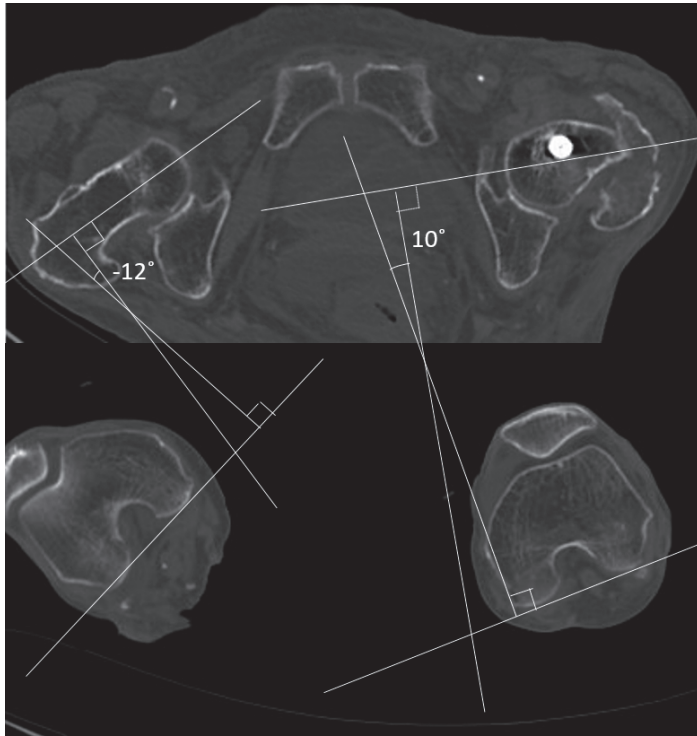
Determination of rotational displacement using CT-torsion measurement according to Jeanmart *et al.* [17]. On the injured left side there is an increase of 22° (10°, 12°) in the rotation angle. This denotes an internal displacement of 22°.
